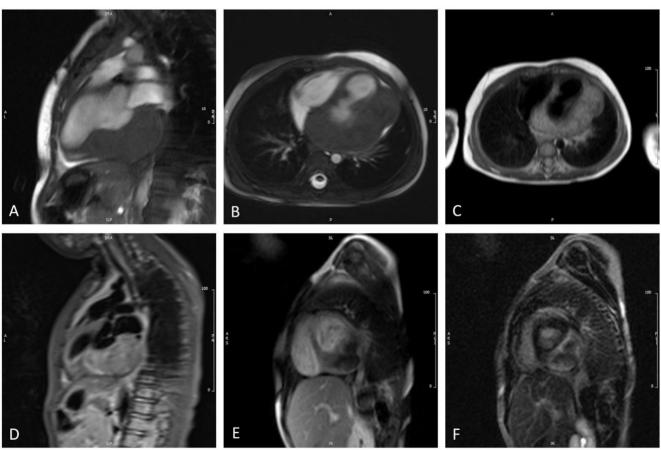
Cardiovascular magnetic resonance imaging of the patient: A) two-chamber true FISP view, depicting an isointensity tumoral lesion confined to the left ventricular inferior wall and extended to the mitral valve; B) the transversal true FISP section, representing the lesion's adhesion to the left ventricular lateral wall; C) hyper-signal intensity on the T2-weighted HASTE transverse image; D) short tau inversion recovery (STIR) sequence, depicting the tumor's hyper-signal intensity on a 2-chamber view; E) peripheral enhancement characteristic on the short-axis early enhancement imaging; and D) delayed gadolinium enhancement (DGE) images, depicting a hyper-enhancement rim around the tumoral mass with a slight increase in signal intensity in the core of the mass
